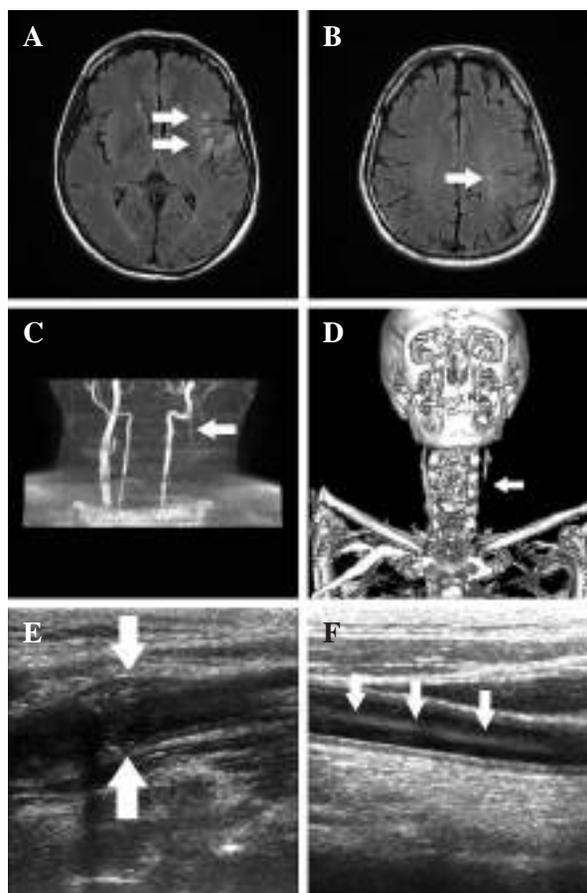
MRI showing acute cortical-subcortical ischemic lesions in the left frontal (A) and parietal lobe (B); MRA showing an occlusion of the left CCA and proximal part of the left ICA (C); CTA reconstruction with the left CCA occlusion (D); CDU showing the ruptured atherosclerotic plaque (E) and occlusion of the left CCA (F)
